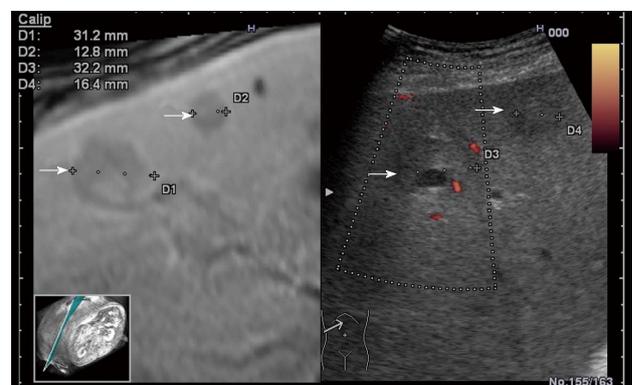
Real-time virtual sonography showing multiple metastases, better depicted on contrast-enhanced computed tomography as compared with ultrasound. A nodule in nodule aspect is visualized with excellent correlation on both contrast-enhanced magnetic resonance and real-time ultrasound.
